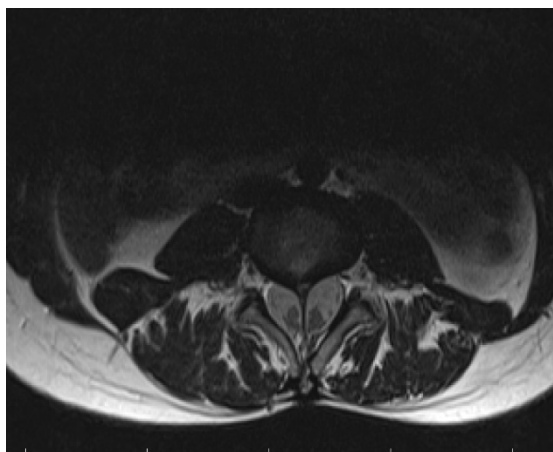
Lumbar spine MRI axial plane showing splitting of the spinal cord
